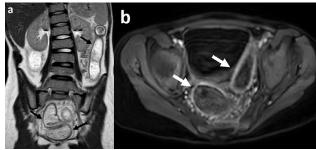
A 10-year-old girl with known ulcerative colitis. Coronal SSTSE T2-weighted image (a) and axial contrast-enhanced T1-weighted with fat suppression image (b) show continuous lesions. Wall thickening (black arrows) in the rectum, sigmoid colon, and descending colon and enhancement (white arrows) are shown.
